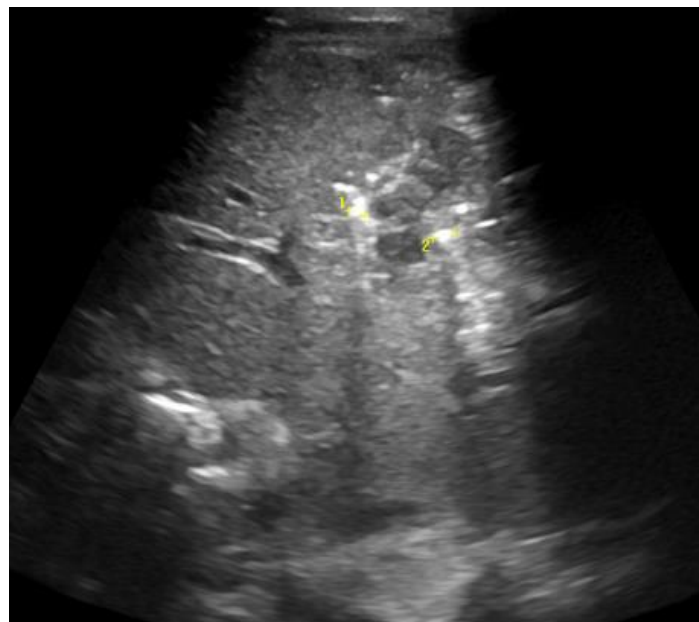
Shrapnel wounds of the liver. On ultrasound, fragments in the liver are visible as luminous inclusions with the acoustic phenomenon of a “comet tail”.
